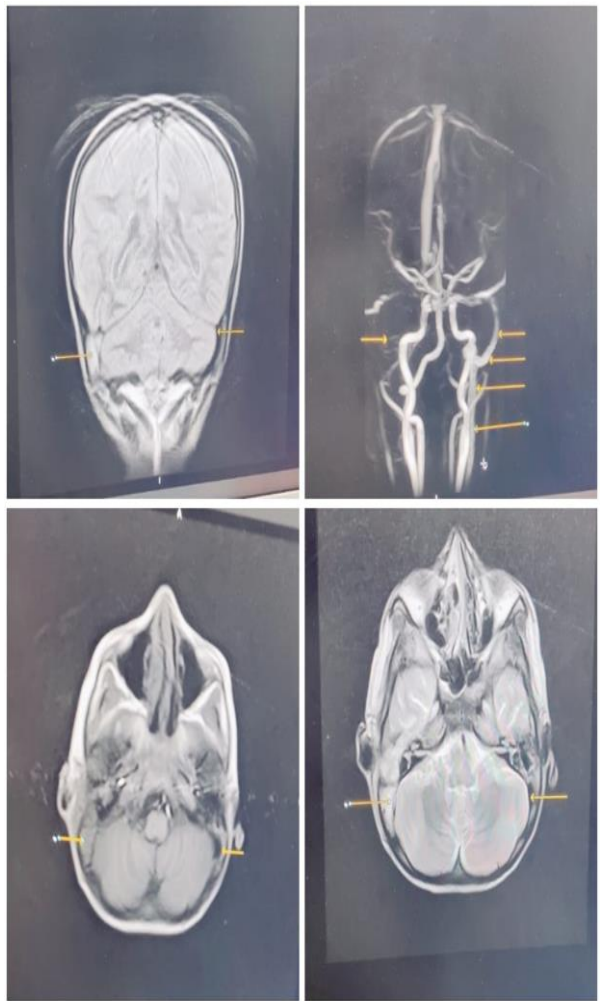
MRI brain with mrv showing right sided otomastoiditis with right sigmoid and right transverse sinus thrombosis extending to right internal jugular vein, mild mucoperiosteal thickening in bilateral ethmoid ear cells.
